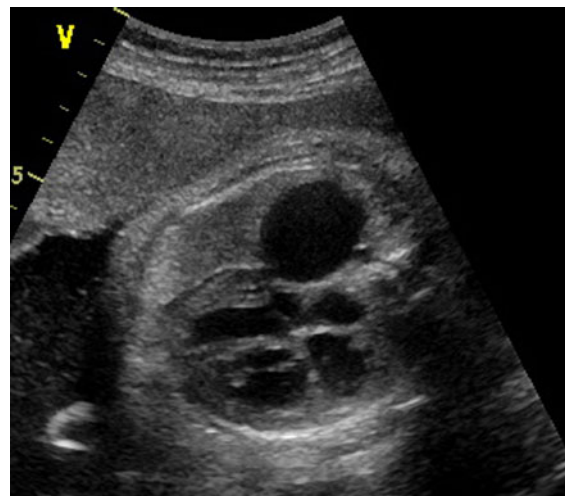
Four-chamber views of fetal echocardiography showing a dilated vascular image behind the left atrium
